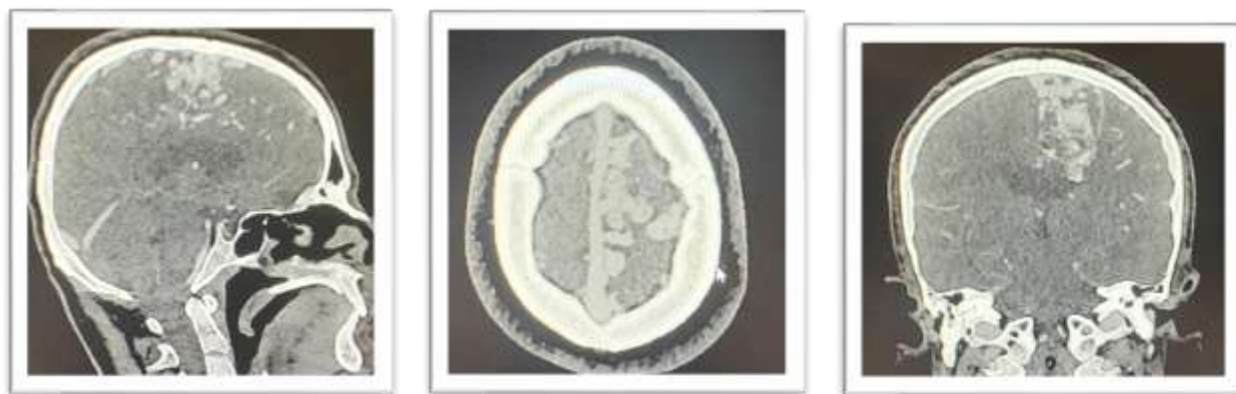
CT angiography-Sagittal, axial and coronal view
